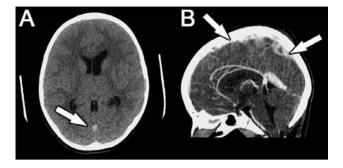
Axial non-enhanced CT scan of the brain A) shows hyperdense focus within the midpart of the straight sinus suggestive of acute thrombus, and CT venography B) showing presence of filling defect at the mid and proximal part of the straight sinus with engorgement of the distal part.
